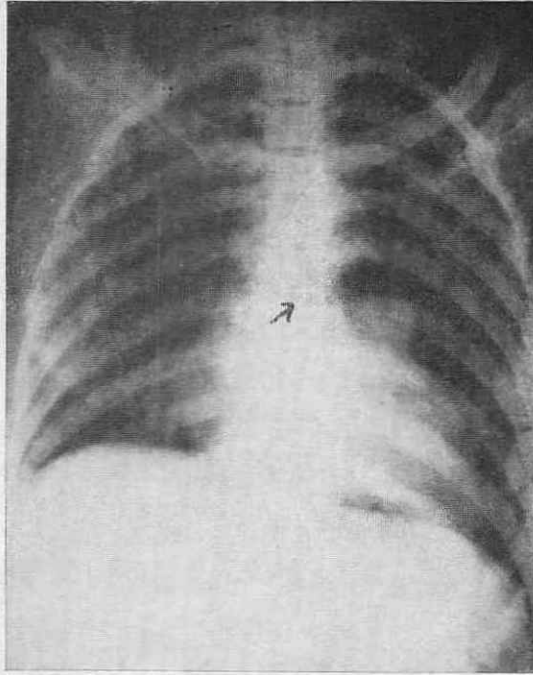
X-ray of the chest showing air in the mediastinum.
